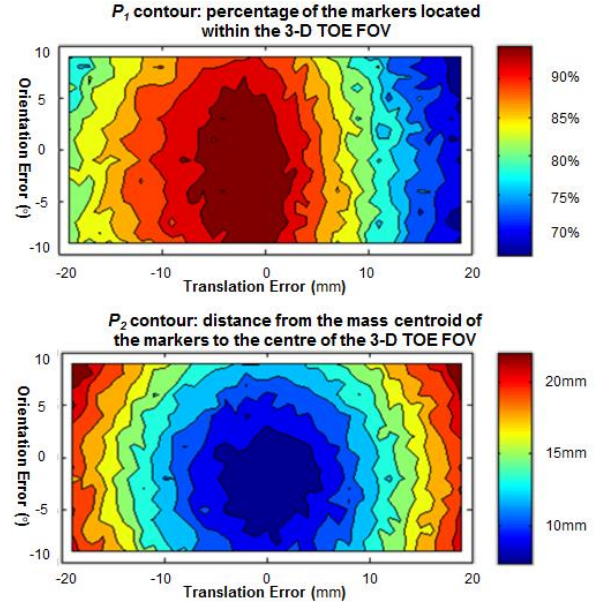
Contour plots showing the effects of the probe positioning errors on the ultrasound image space.
